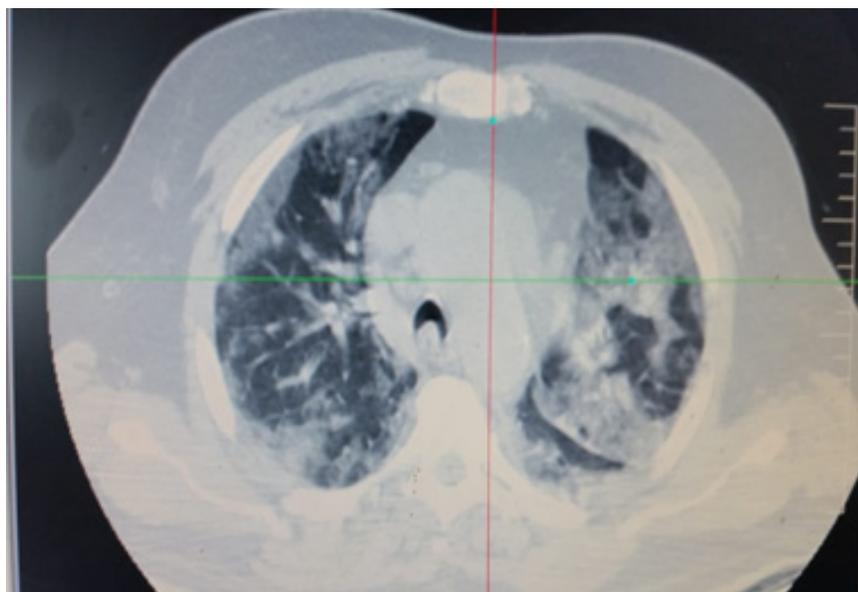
CT axial view of the same patient showing a diffuse ground glass of both lungs.
